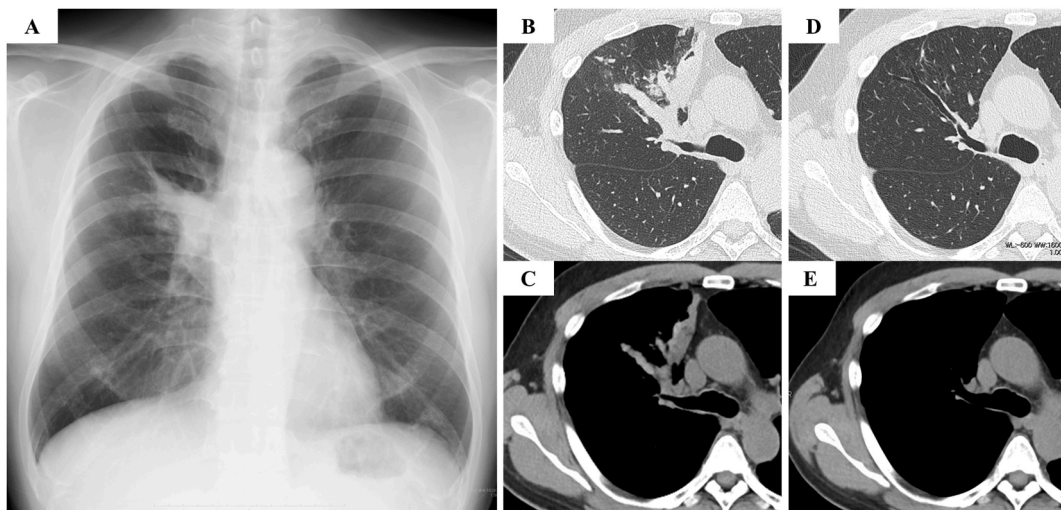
Chest imaging findings. Chest X-ray showing central consolidation with band-like infiltrate in the right middle lung field (A). High-resolution CT showing mucus plugs with HAM and concomitant peripheral consolidation in the S³ segment of the right upper lobe (B, C). Resolved mucus plug and consolidation leaving residual central bronchiectasis at eight months after ICS/LABA treatment (D, E).
